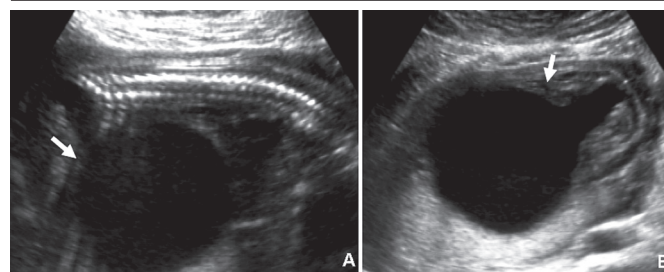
22-week ultrasound scan showing distended bladder (A) and the keyhole sign (B), suggestive of the LUTO (see white arrows)
